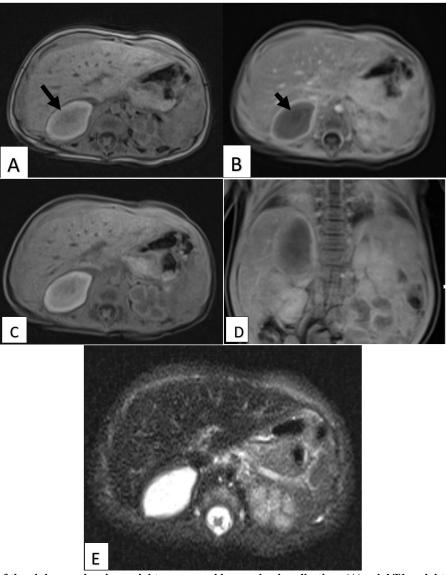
MRI of the abdomen showing a right suprarenal hemorrhagic collection: (A) axial T1-weighted image before contrast demonstrating heterogeneous hypersignal, (B) axial T1-weighted image after gadolinium injection without significant internal enhancement, (C) axial T1-weighted fat-saturated image before contrast better depicting the intrinsic T1 hypersignal of blood, (D) coronal T2-weighted HASTE image showing heterogeneous hyperintensity of the lesion, and (E) axial diffusion-weighted image (b1000) demonstrating marked hyperintensity with corresponding ADC restriction
